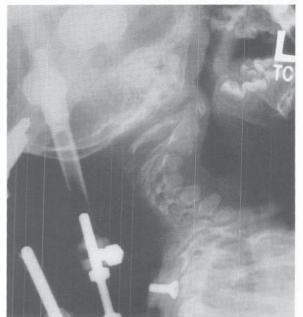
Diastrophic dysplasia. A, Clinical appearance. B, Lateral cervical radiograph. Because of the severe kyphosis, the odontoid is horizontal. C, Radiograph showing gradual correction by means of the halo-Ilizarov distraction technique prior to fusion (see Fig. 10–24).
